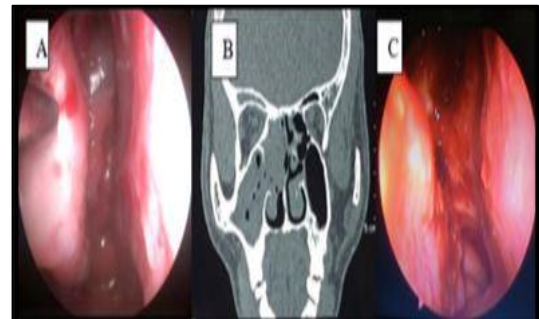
(A) DNE image of right nasal cavity showing sinonasal mass in the middle meatus. (B) CT PNS coronal view showing homogenous opacity in right maxillary sinus and nasal cavity. Post-operative 6 weeks endoscopic image of cleared sinonasal mass.
